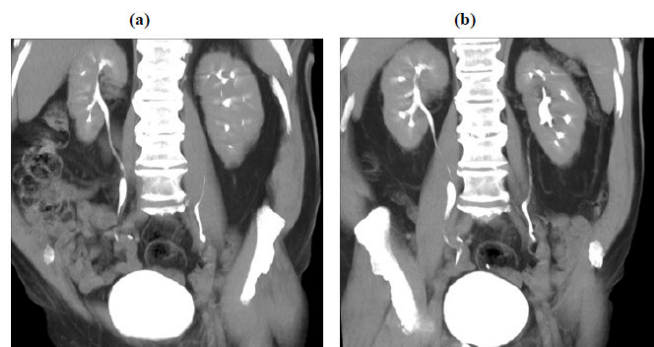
The CT image in the coronal oblique MIP reformat images showing the course of the ureter adjacent to the ureteral diverticulum (a) and the ureter entry point of the diverticulum (b).
